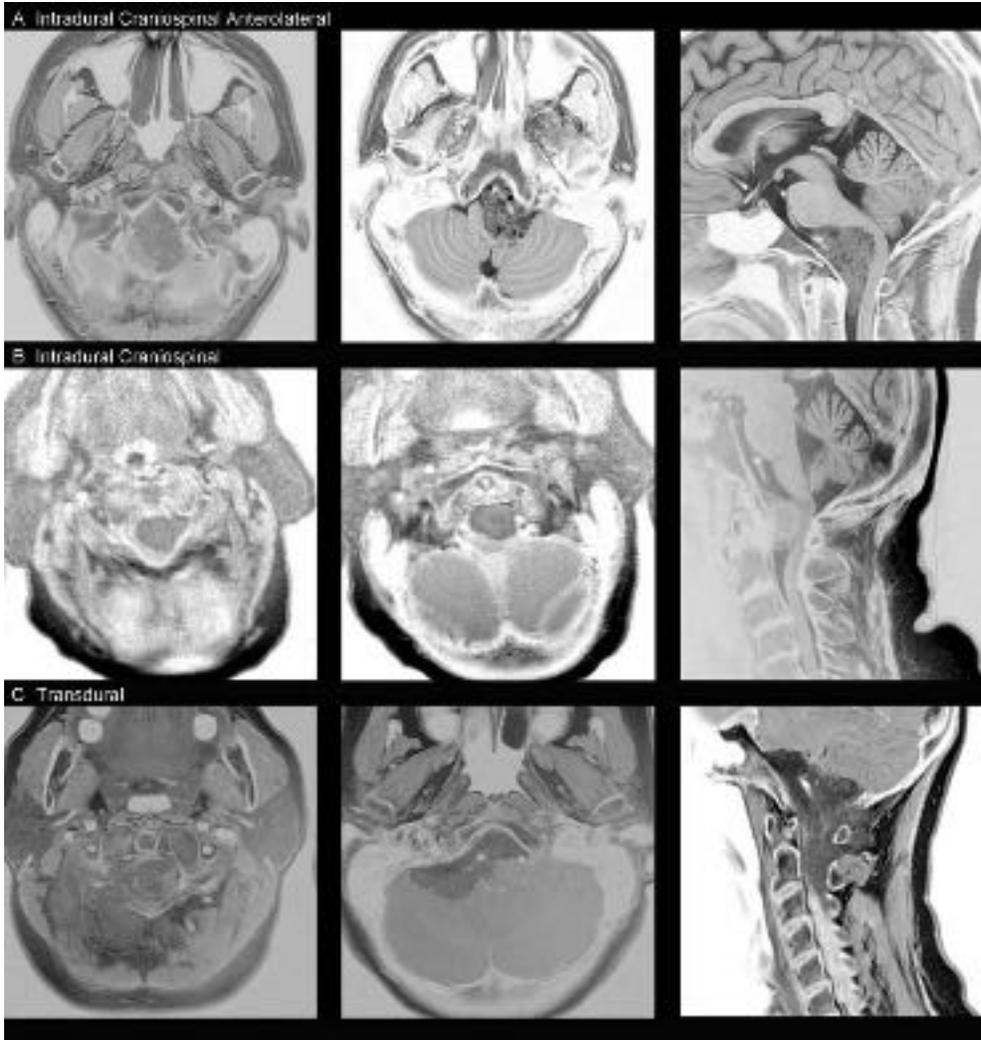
Classification of foramen magnum (FM) meningiomas on magnetic resonance imaging and computed tomographic scans. (A) An intradural, craniospinal, anterolateral tumor displaces the medulla posteriorly and contralaterally, opening the surgical corridor, encasing the vertebral artery (VA). Note that on the T2 images (central and right) there is no T2 hypersignal. This meningioma was easily dissected from the brain stem and VA. (B) An intradural craniospinal tumor that is primarily anterior but also displaces the upper cord and medulla posterolaterally thus opening the access corridor for surgical resection. The VA is pushed up against the brain stem. (C) A transdural foramen magnum meningioma. This tumor transgressed the dura and the adventitial sheath of the VA. The patient presented with multiple cranial neuropathies, cerebellar deficits, and long tract findings. The tumor had an extensive intracranial base as well and was extremely firm and fibrous in the extradural component. The intradural component was dissectible from the VA and softer in consistency. Its adherence and firm texture with invasion of the extradural adventitial sheath led to a radical but incomplete resection. Decompression of the brain stem, upper cord, and cerebellum allowed a rapid clinical improvement.
